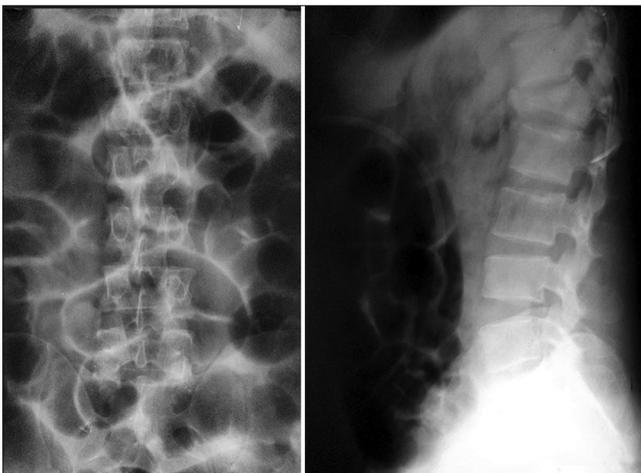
Anteroposterior and lateral X-ray showing L2 vertebra fracture.
